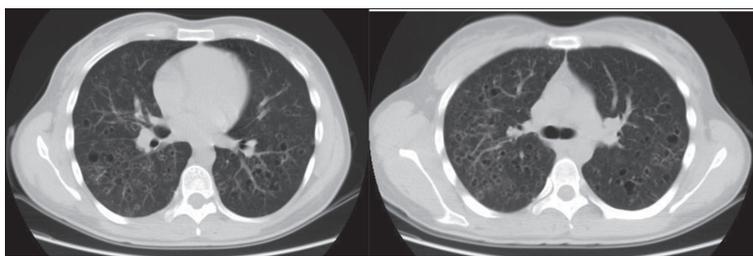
Initial chest high-resolution computed tomography of the patient with pulmonary Langerhans cell histiocytosis
